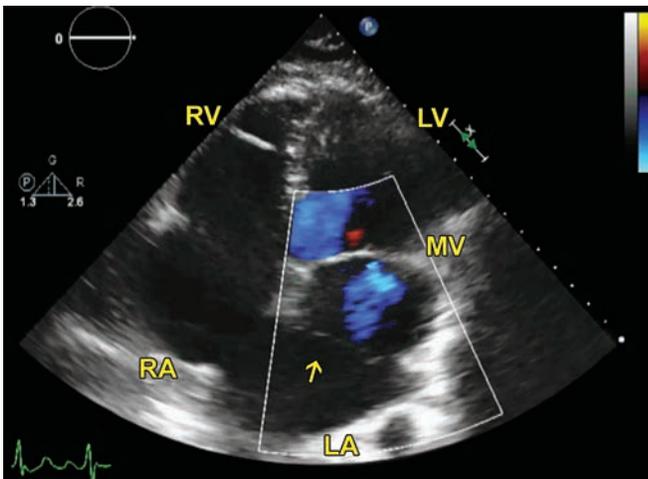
Transthoracic apical 4-chamber view. Arrow points to a linear echodensity in the left atrium.
